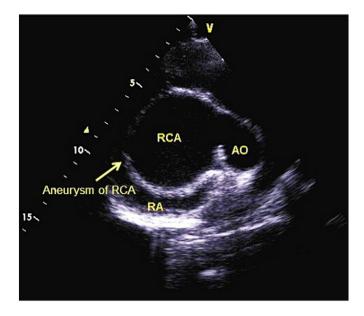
Echocardiogram of an aneurysmally dilated right coronary artery fistula to right atrium in the parasternal short axis view. (RCA: right coronary artery; AO: ascending aorta, RA: right atrium).
